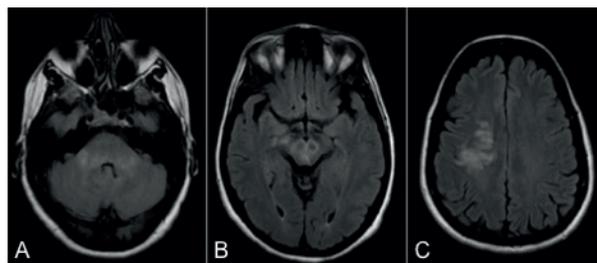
Brain MRI 4 weeks after onset. (A) (B) and (C) Axial FLAIR images. Diffuse patchy hyperintensities at the pons and middle cerebellar peduncles. De novo lesions involving the mesencephalon and right centrum semiovale.
